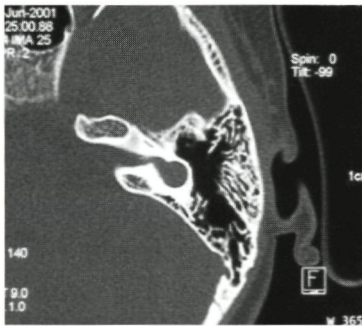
Patient 10a, CT scan, axial view of the left petrosal bone: common cavity, aplastic semicircular canals.
